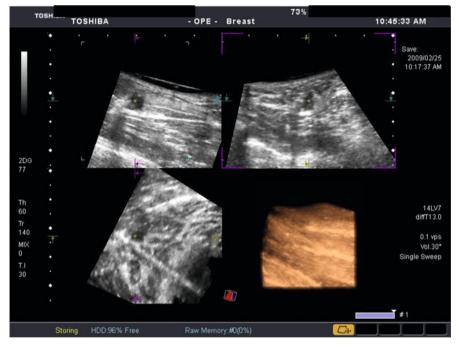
Confirmation of the location of the needle using 4D probe. With ultrasound imaging in the two planes, we ensured that the electrode was located in the center of the lesions using linear 2D probe for the vertical image and 4D probe for the coronary image
